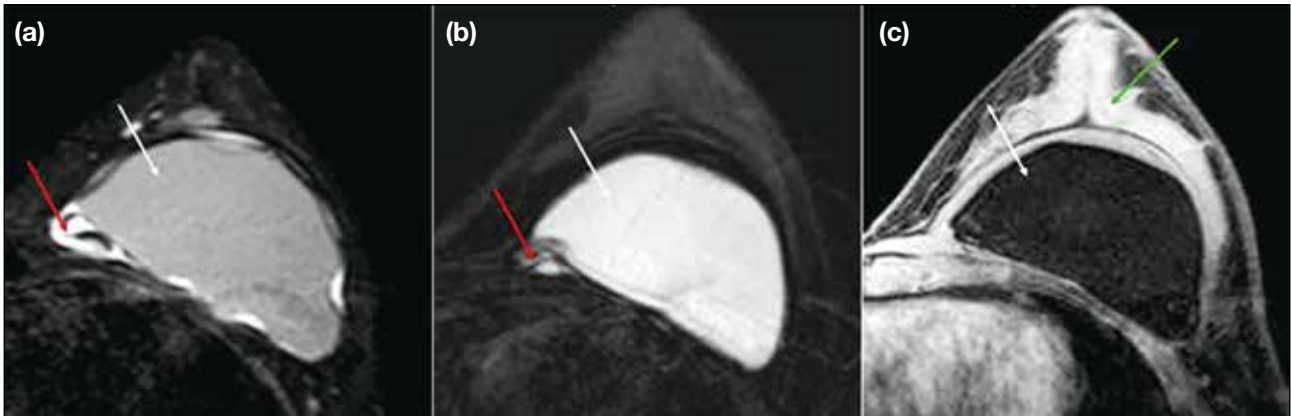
Double-lumen implant, with silicone gel in the inner lumen (white arrows) and saline solution (red arrows) in the smaller outer lumen. (a) Short-tau inversion recovery magnetic resonance imaging showing the hyperintense outer lumen containing saline solution (red arrow), and (b) a silicone-only sequence showing a hyperintense inner lumen containing silicone gel (white arrow). (c) The silicone gel signal is suppressed on the silicone-suppressed sequence (white arrow). The breast parenchymal tissue is indicated by the green arrow.
